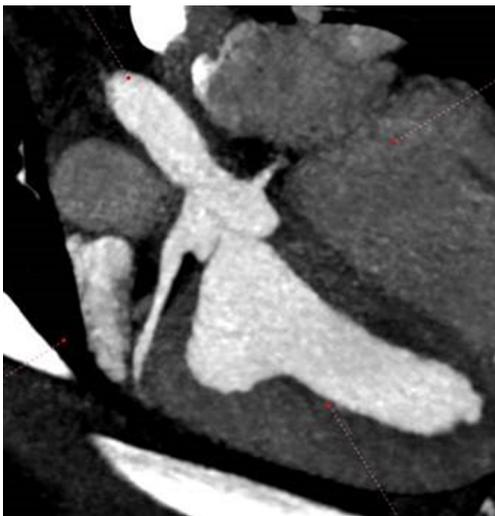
Postoperative CT study image showing co-adaptation of the tissue engineered patch and the native aortic valve leaflet.
